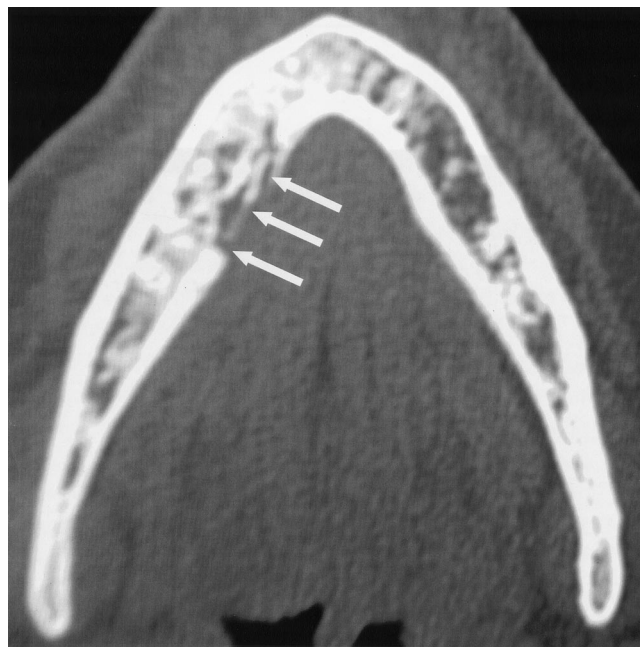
Axial view of a computed tomographic scan with contrast showing a lytic radiolucency along the medial aspect of the body of the right mandible with erosion of the lingual cortex in the region of the second bicuspid and first molar.
